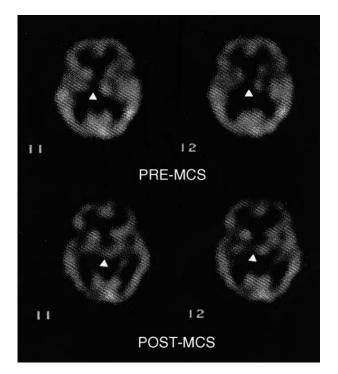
SPECT pre- (*top*) and post-cortical (*bottom*) stimulation showing renormalization of thalamic rCBF
